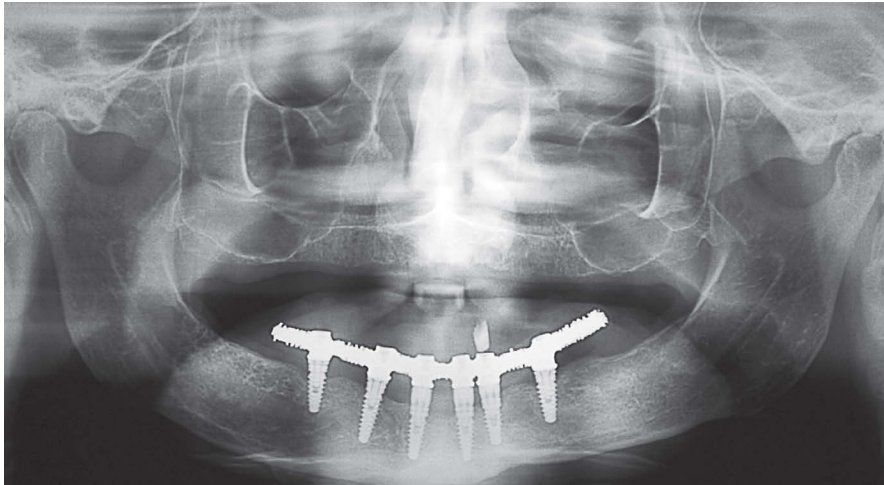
Panoramic radiograph after rehabilitation.
